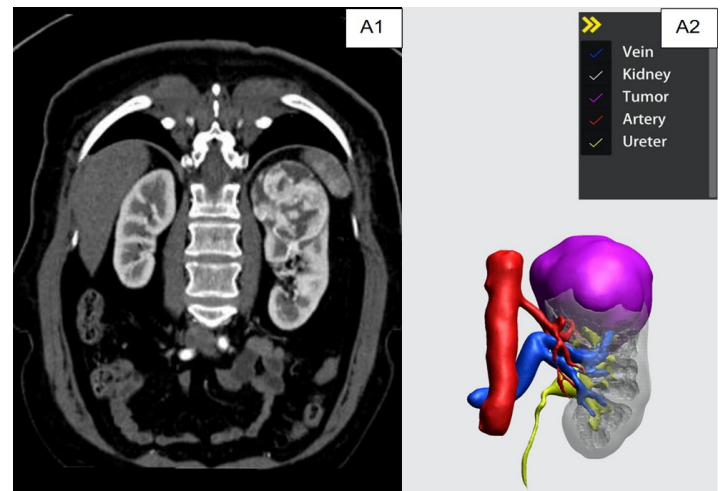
Computed tomography image with 3D reconstruction of a kidney lesion. Female patient, 58 years old, with a tumor lesion in the left kidney suggestive of neoplasia. A1: coronal computed tomography section. A2: 3D image reconstruction. Nephrometry shows an R.E.N.A.L. score of 11 points (highly complex lesion). Source: personal file.
